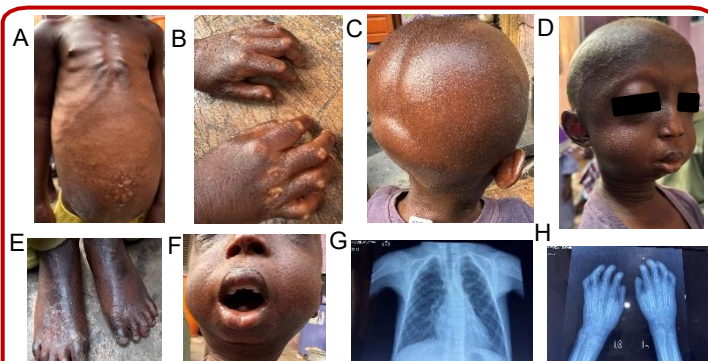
Phenotypic presentation of MADA. A) Narrow shoulders with absent clavicles B) Lipodystrophy at joints C) Delayed closure of cranial sutures and alopecia D) Micrognathia with bird-like facies E) Flaking of skin F) Dental crowding G and H) Chest and hand X-rays showing missing clavicles and distal phalanges, respectively.
